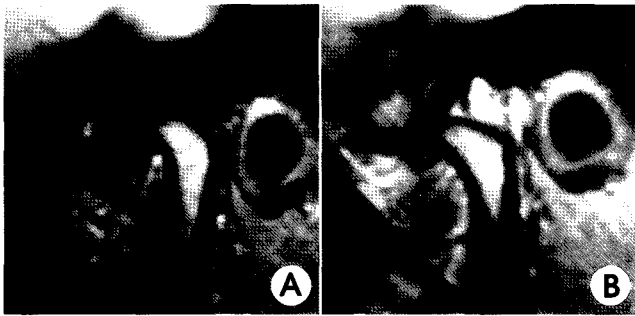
MR images show anterior disc displacement with reduction (A: close, B: open).
